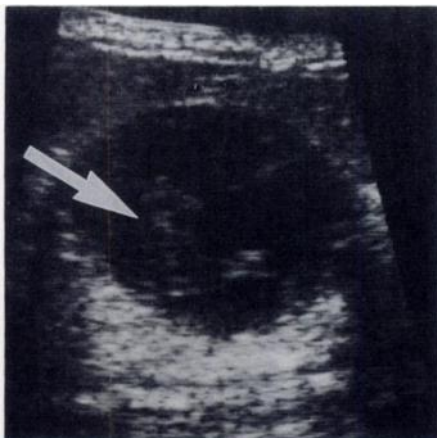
Sonogram of intracystic carcinoma. Echogenic tumor (arrow) is growing in wall of cyst.
